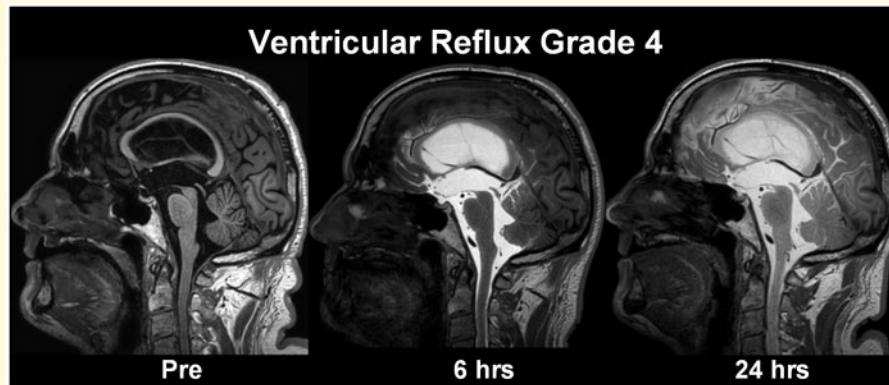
Abbreviations: BBB = blood–brain barrier; CSF = cerebrospinal fluid; DESH = disproportional enlarged subarachnoid space hydrocephalus; ERC = entorhinal cortex; gMRI = glymphatic magnetic resonance imaging; ICP = intracranial pressure; iNPH = idiopathic normal pressure hydrocephalus; MTA = medial temporal atrophy; MWA = mean ICP wave amplitude; REF = reference patient; ROC = receiver operating characteristics; ROI = region of interest
